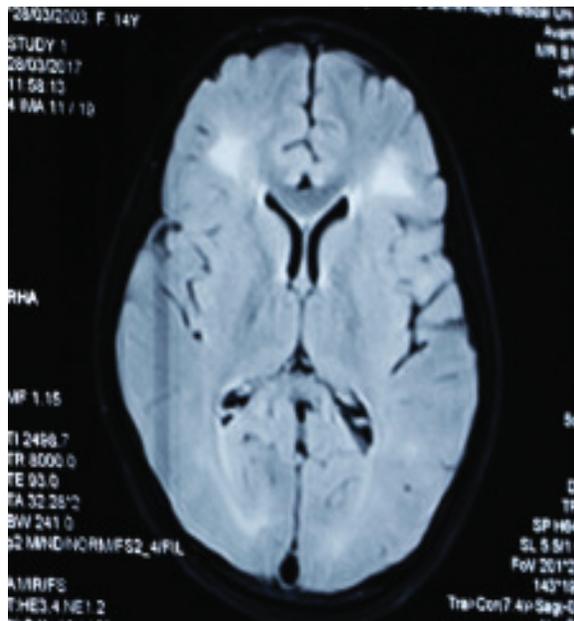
MRI of Brain with contrast showing metachromatic leucodystrophy at both frontal and periventricular region.
